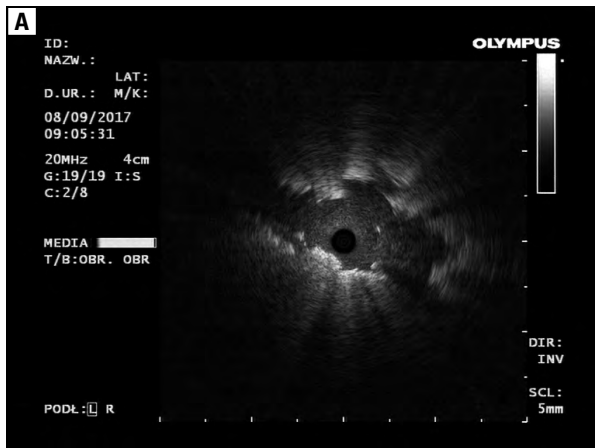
Ultrasound imaging of interstitial lung infiltration obtained with radial endobronchial ultrasound mini-probe (rEBUS). A. Cryptogenic organizing pneumonia; B. Usual interstitial pneumonia. With the consent of the Archives of Endoscopy Unit of Pulmonary Hospital, Zakopane
